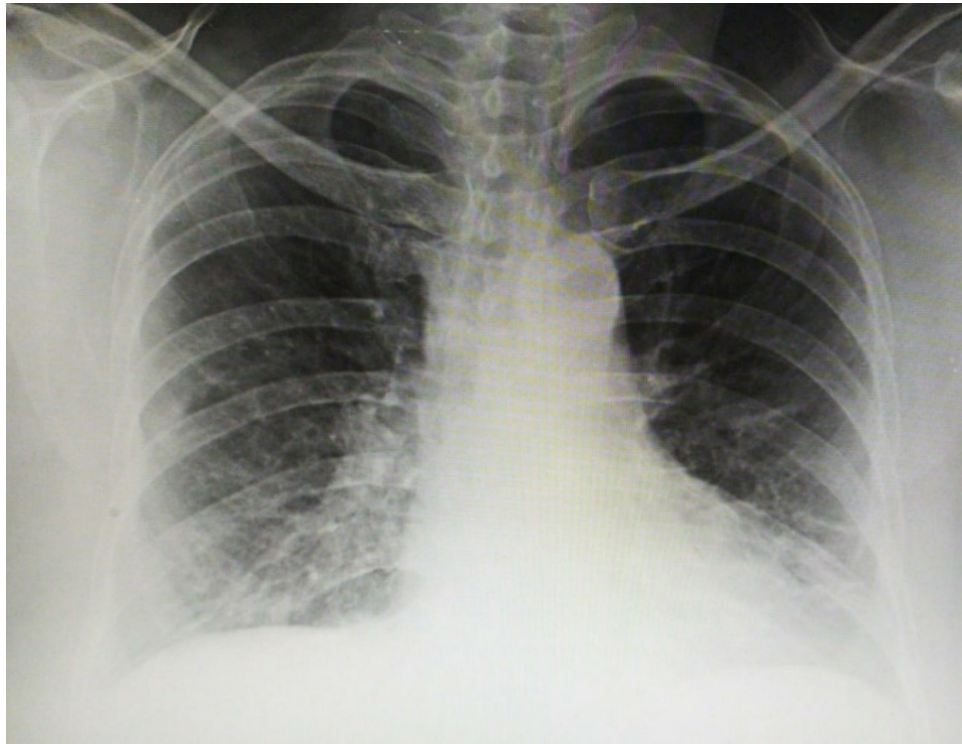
Chest X-ray of a COVID-19 patient
